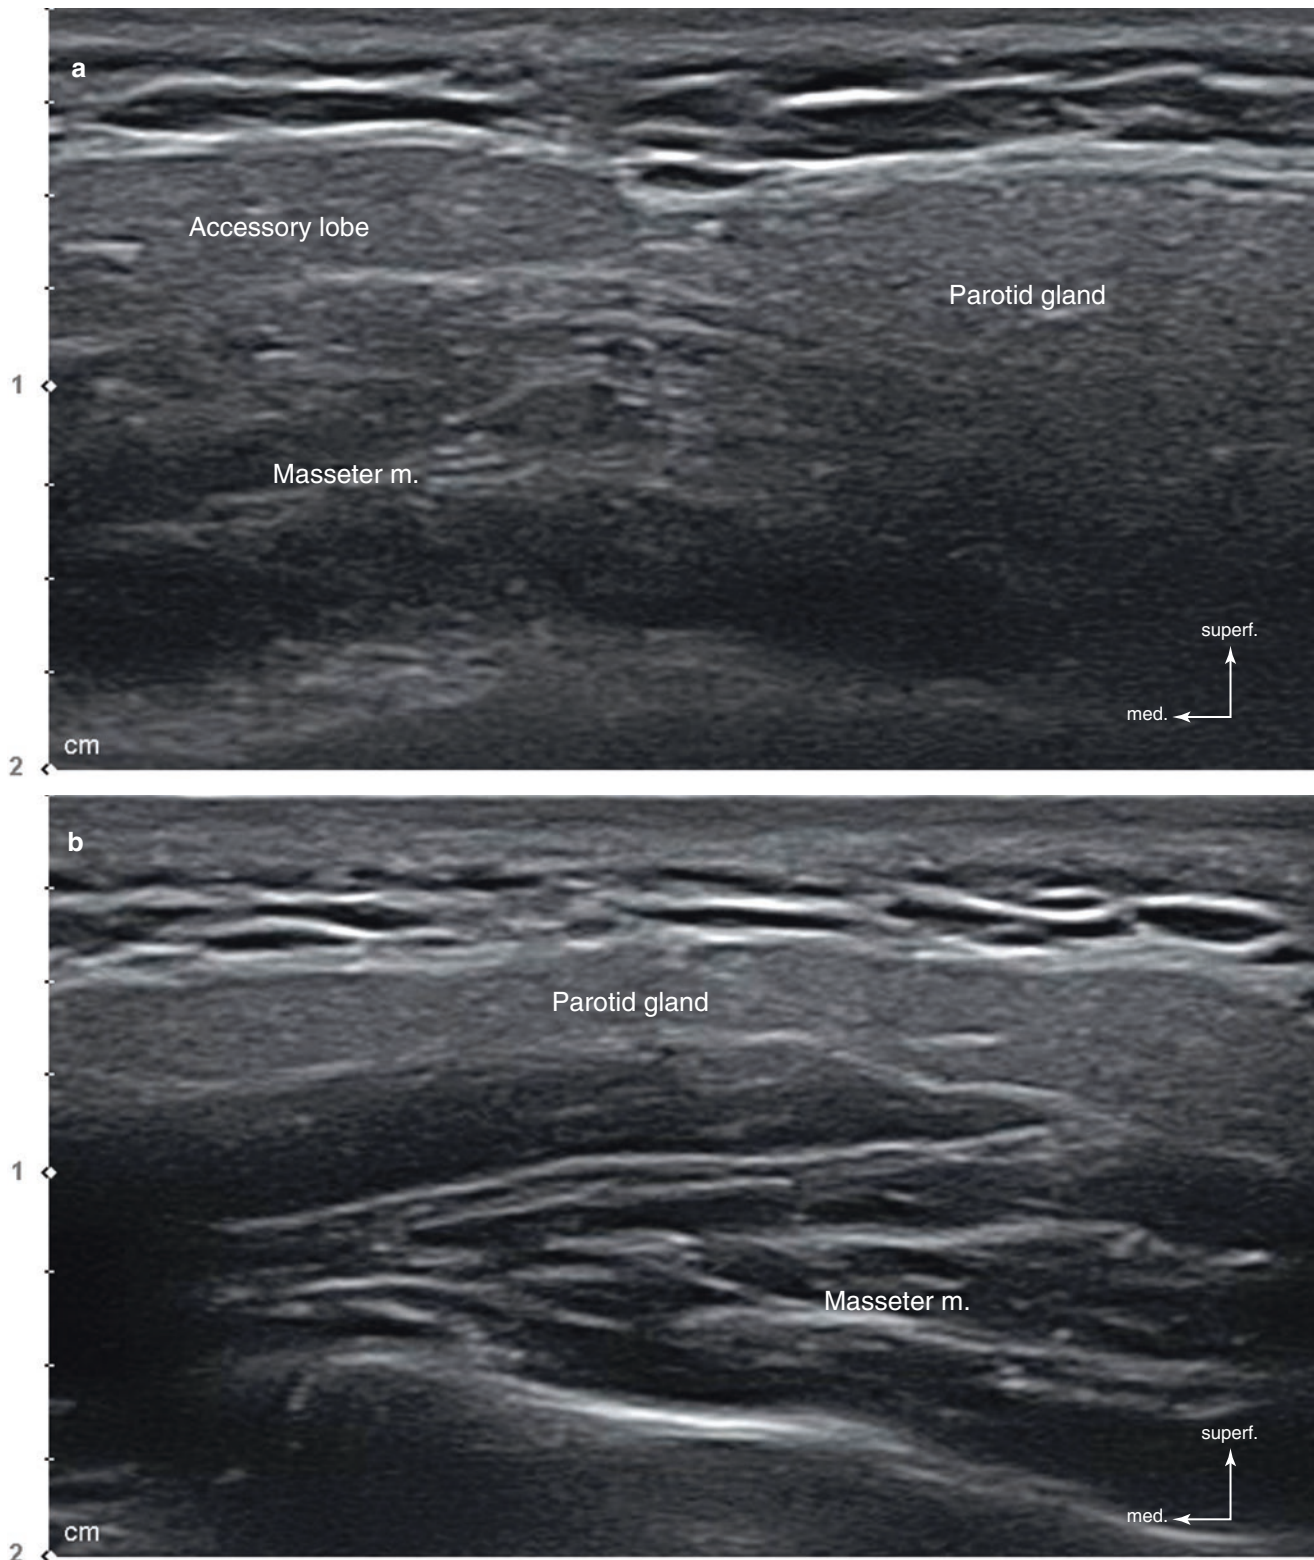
Ultrasonography of the parotid gland. (a) Accessory gland covering the masseter muscle partially, B mode (transverse view, 15 MHz by linear transducer) and (b) parotid gland covering the whole
